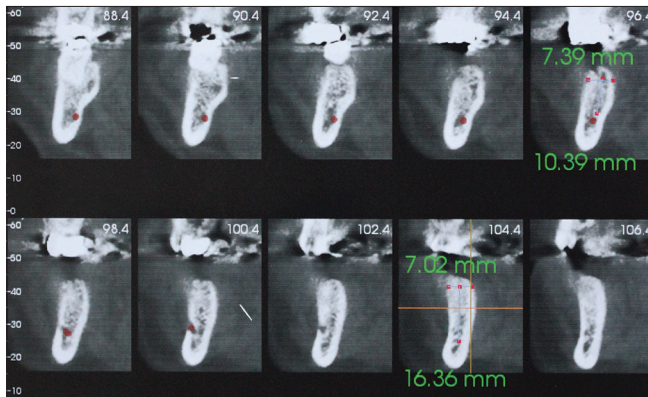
Postoperative cone beam computed tomography
